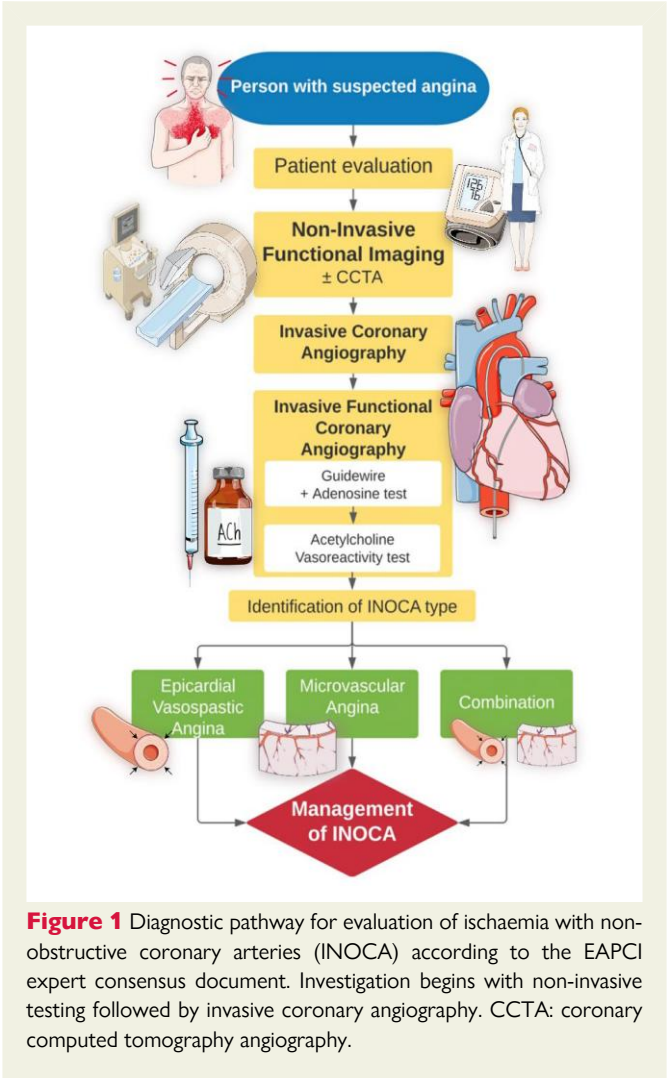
Diagnostic pathway for evaluation of ischaemia with non-obstructive coronary arteries (INOCA) according to the EAPCI expert consensus document. Investigation begins with non-invasive testing followed by invasive coronary angiography. CCTA: coronary computed tomography angiography.
